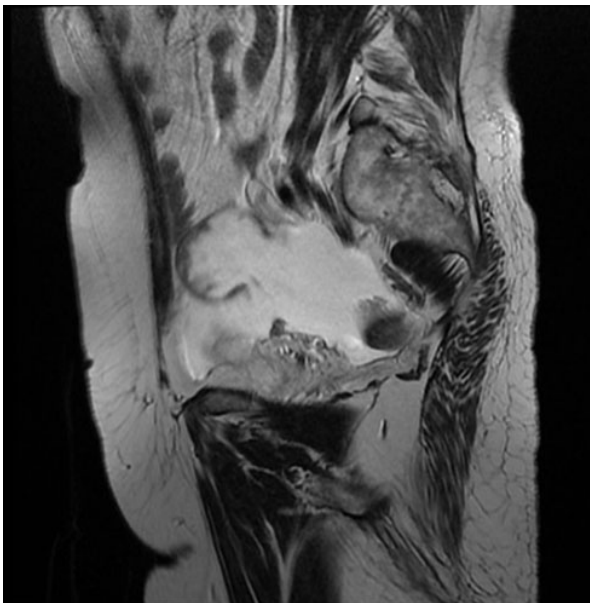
MRI T2-weighted sagittal cut showing cystic formation in the right iliac fossa with a hypointense thin-walled, open in the large peritoneal cavity with ascites of moderate abundance.
